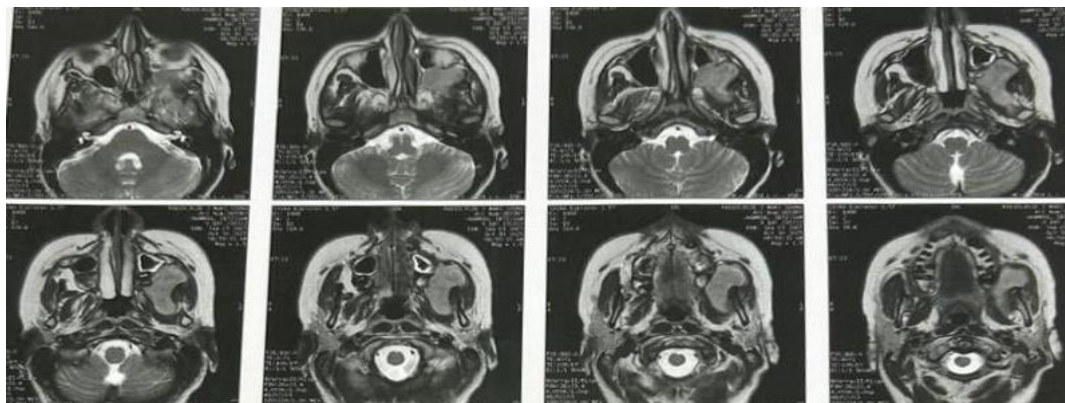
Preoperative axial MRI sequences demonstrating the infratemporal and parapharyngeal mass.
